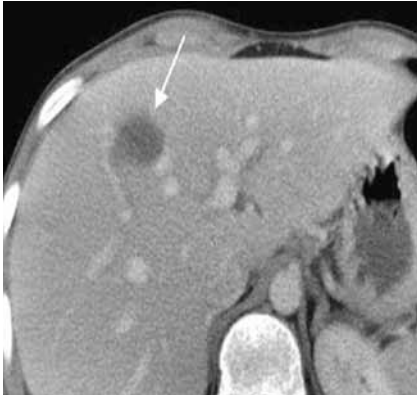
Abdominal CT demonstrates the presence of a hypodense non-enhancing liver lesion of 1.5 cm (arrow).
